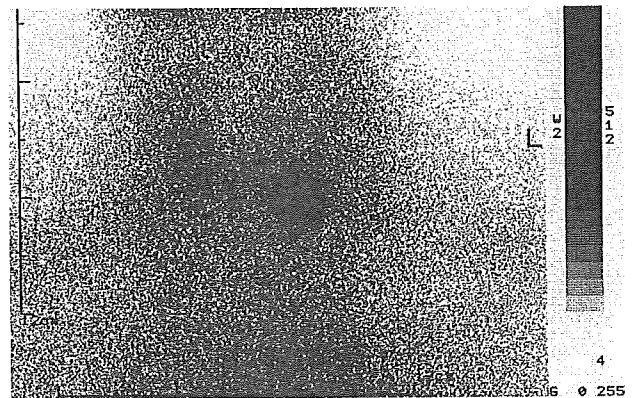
Thyroid ^{99m}Tc scintigram demonstrating a hot nodule in the left lobe. The rest of the gland shows suppressed activity.
